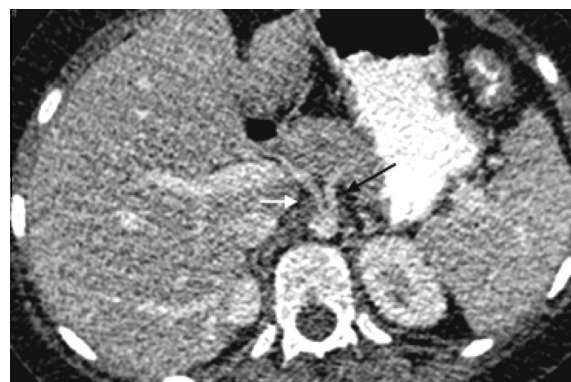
Post contrast CT of the abdomen axial image showing separate origin of the common hepatic artery (white arrow) and splenic artery (black arrow) from the aorta.
